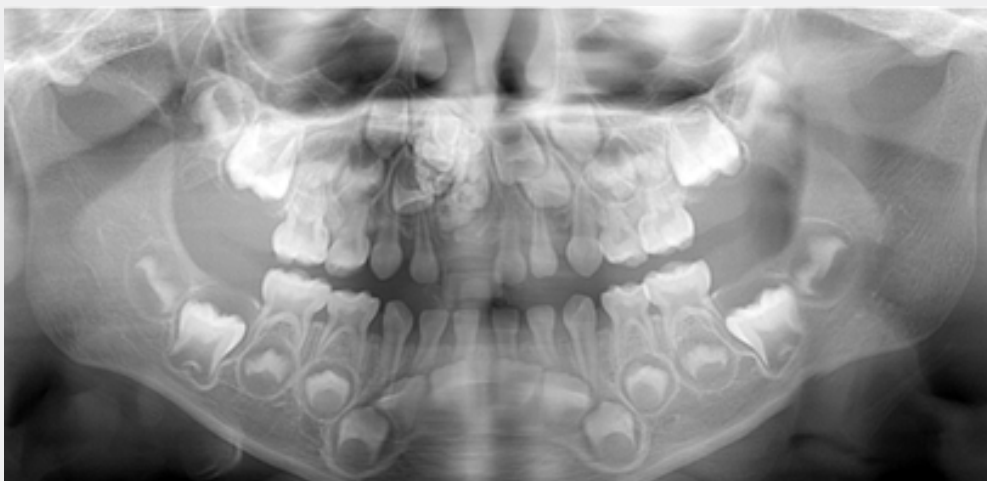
Orthopantomography.
